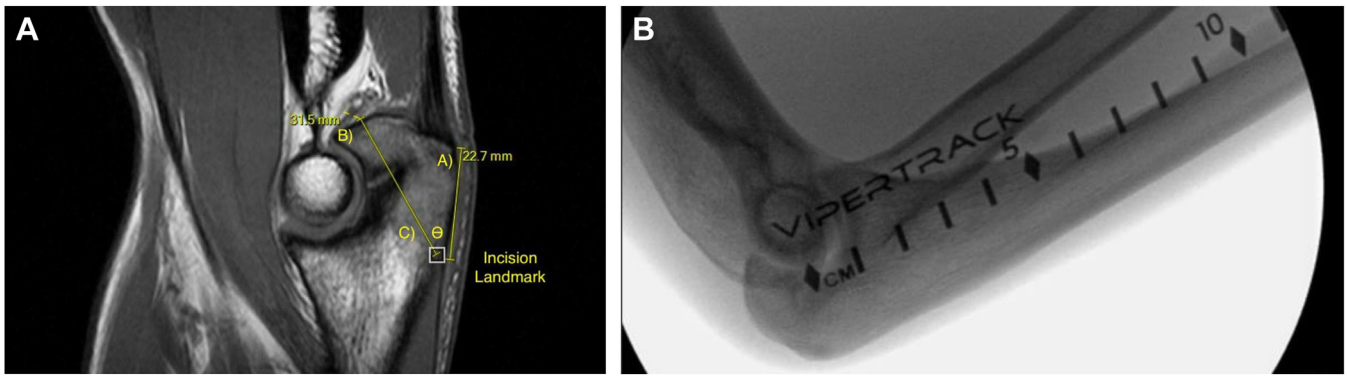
(A) Preoperative sagittal MRI measuring incision landmark from triceps footprint to desired starting point for screw. (B) Radiographic ruler used to plan out start point for K-wire based on preoperative MRI measurements. MRI, magnetic resonance imaging.
